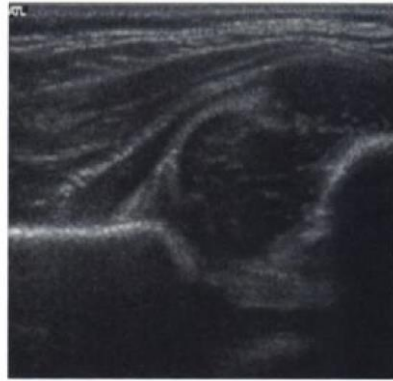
Coronal section in the "standard plane" of a normal hip, oriented in the way the ultrasound equipment displays it. Alpha angle = 67°, Beta angle = 49° = superior, L = lateral, I = ilium, BA = bony acetabulum, FH = femoral head.
